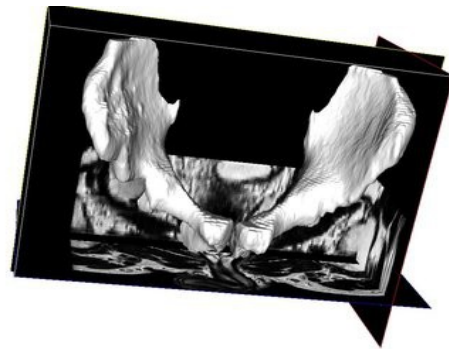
A statistical shape model based on the shape of the pelvis in 21 adult males is used to extract the shape of the pelvis from the preoperative MRI data.
